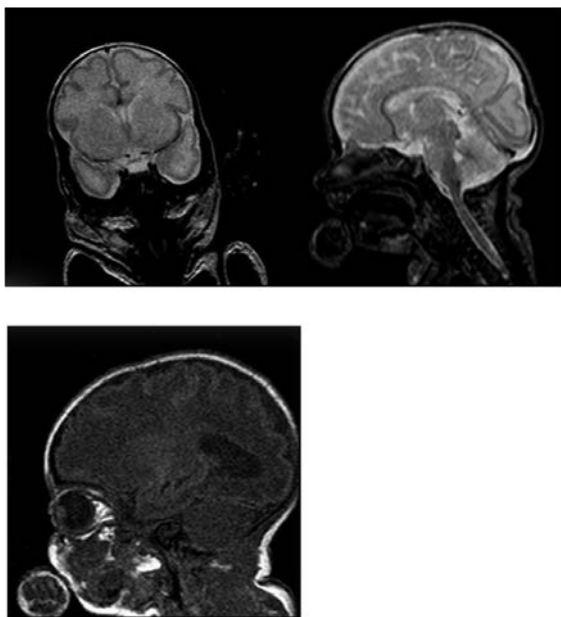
Cranial and hypophysis-hypothalamic magnetic resonance imaging was normal (a: coronal T2, b: sagittal T1, c: sagittal T2).
